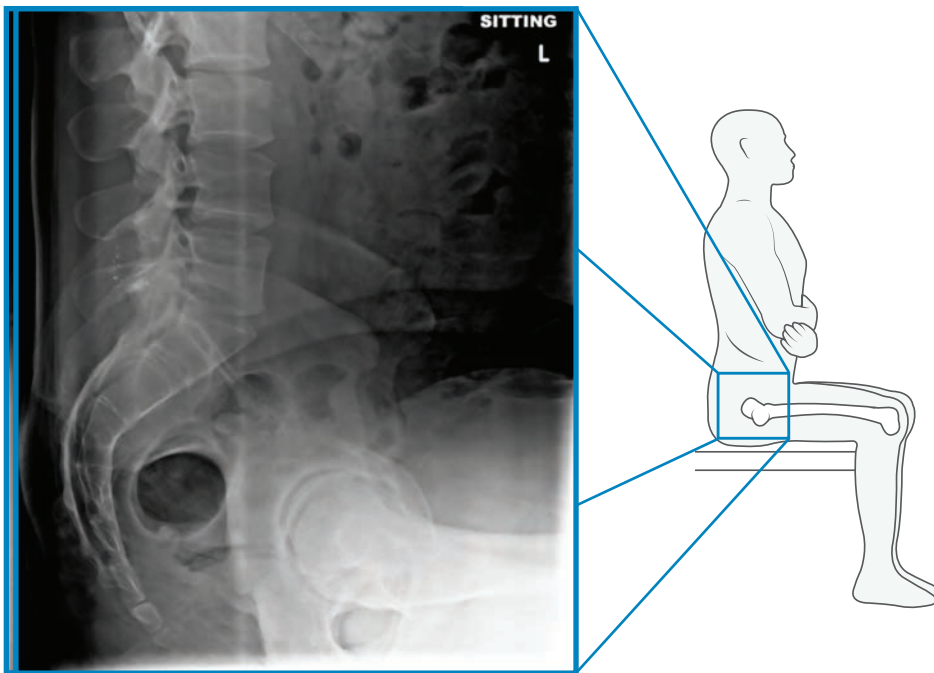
Preoperative Lateral Sitting X-ray
